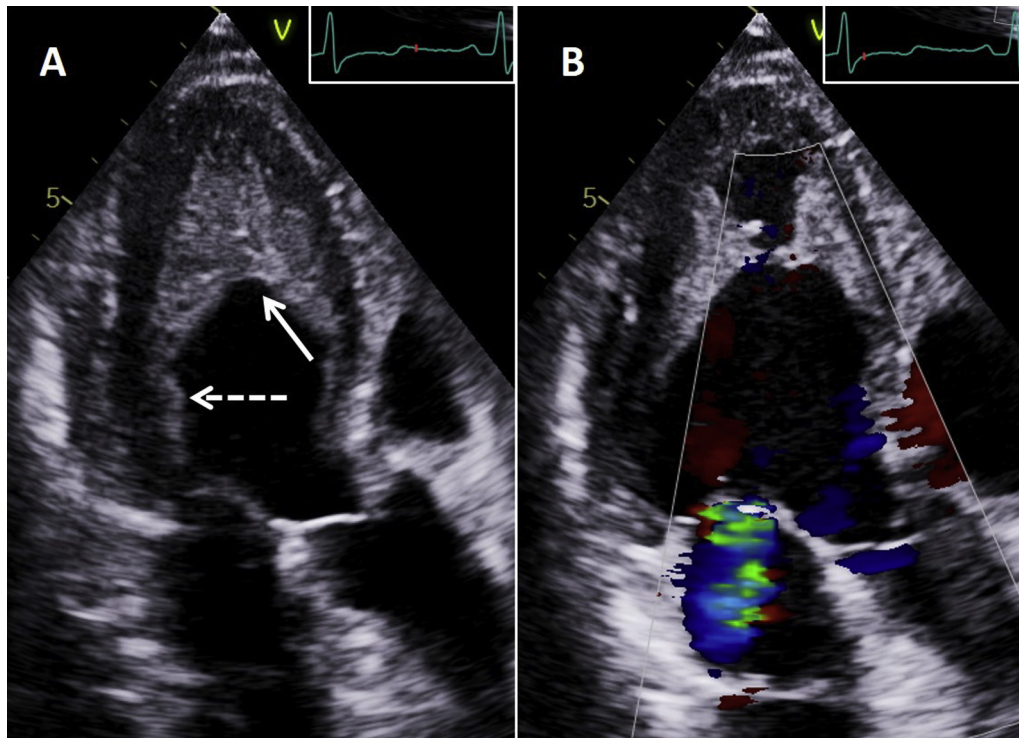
(A) Two-dimensional TTE apical long-axis view depicting thrombus (solid arrow) involving the posteromedial papillary muscle and entrapping the chordae (dotted arrow) in a patient with LE. Color Doppler showed mild, new-onset, mitral regurgitation as a consequence of the tethering of the MV leaflets (B).
